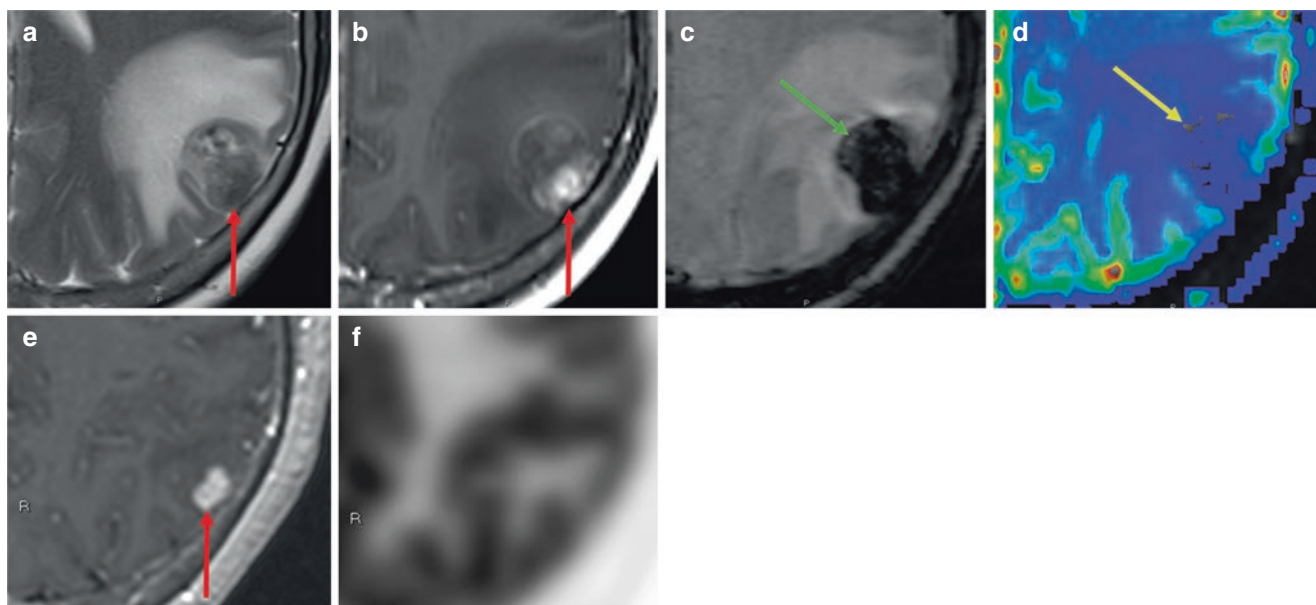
Cerebral Metastasis. Tumor Progression. Melanoma metastasis of the left parietal lobe. Axial T2-weighted MRI (a), axial post-contrast T1-weighted MRI (b), axial susceptibility-weighted MRI (c), and axial DSC perfusion-weighted MRI corrected cerebral blood volume map (d) obtained at 10 months following radiosurgery. A discrete nodular focus of intermediate T2 signal (red arrow in a) very closely matches the area of post-contrast enhancement (red arrows in b), the T1/T2 match sign of recurrent tumor. Magnetic susceptibility from tumor-related hemorrhage (low intralésional signal in G; green arrow) is
